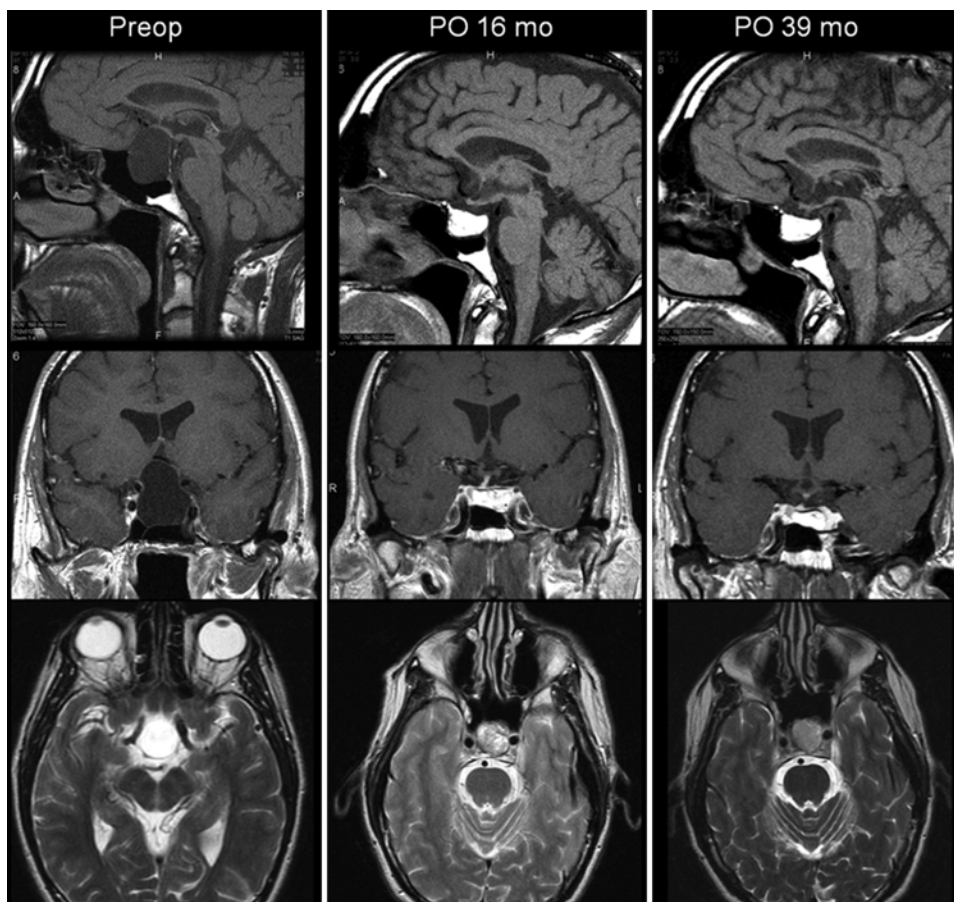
Case 1. Sagittal (upper row), coronal (center row), and axial (lower row) MR images showing minimal fat resorption over time. Preoperative imaging (left column) documents an intrasellar AC with suprasellar extension. Postoperative imaging at 16 (center column) and 39 months (right column) shows minimal fat resorption and no cyst recurrence.
